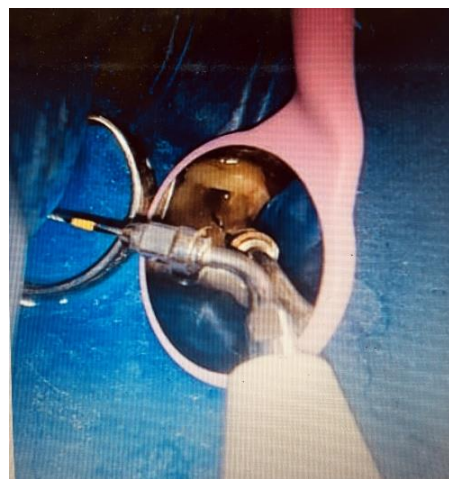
Using Passive Ultrasonic Irrigation
